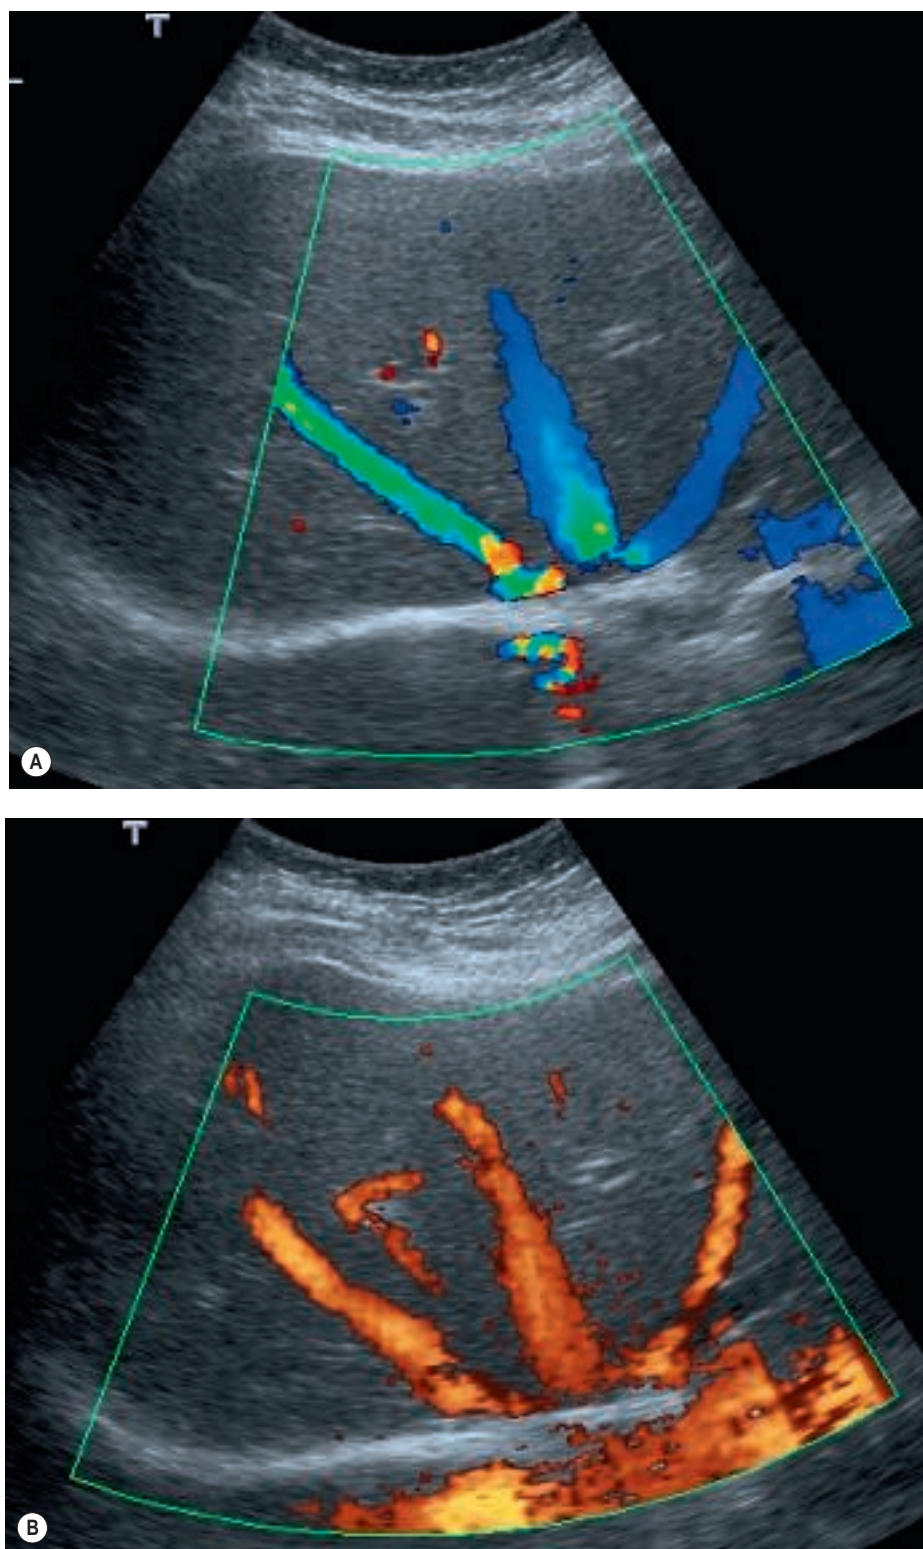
• Colour Doppler of the hepatic vein confluence. Flow is coloured blue to indicate a direction away from the transducer.
